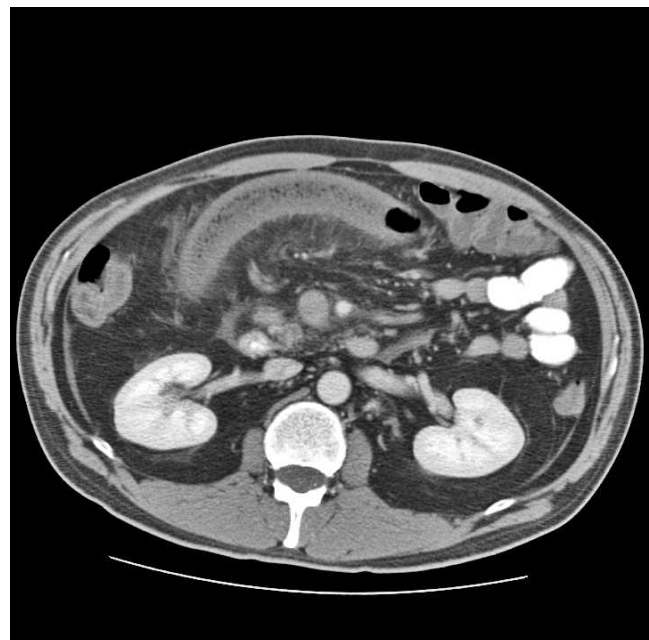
Computed tomographic scan showing thickened loops of small bowel.
